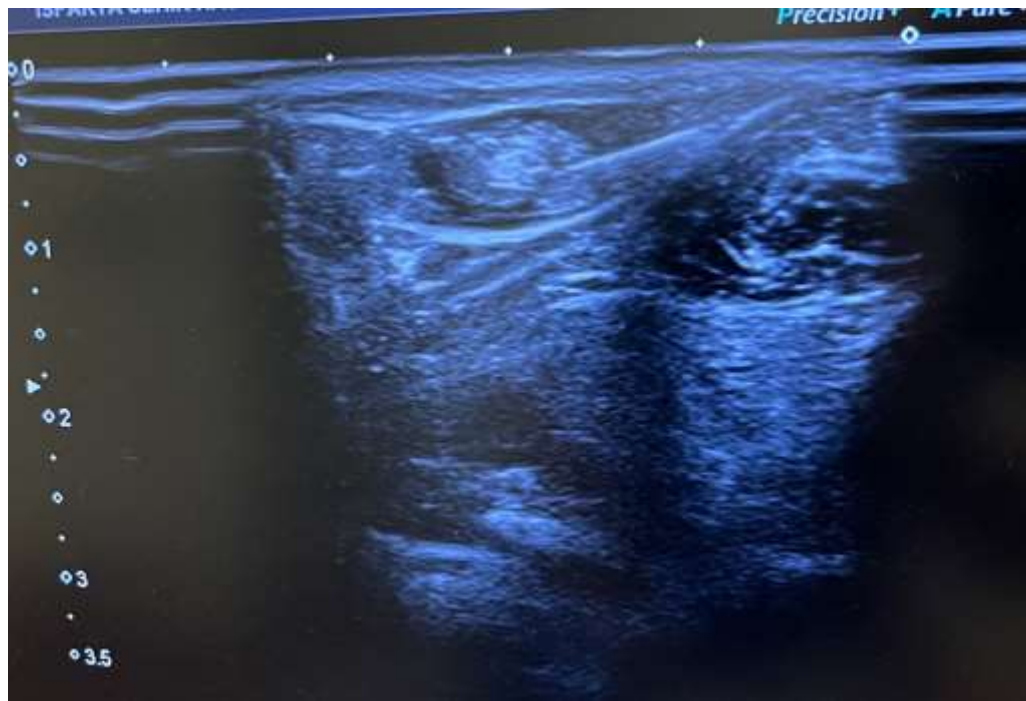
Ultrasound-guided sural nerve phenol injection
